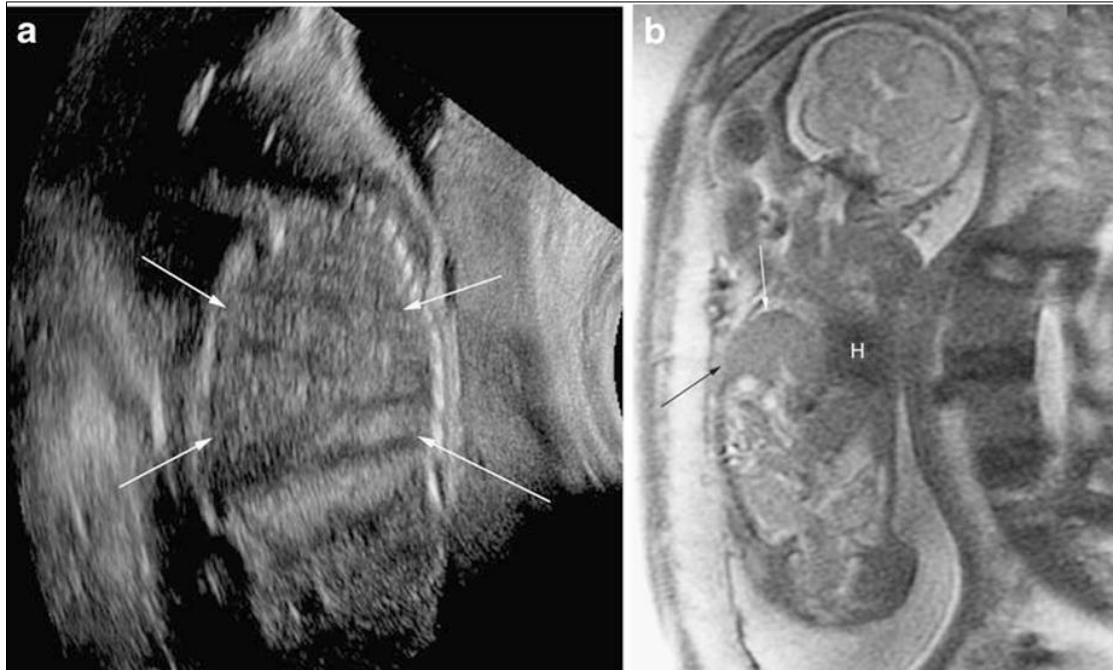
Right Bochdalek hernia in a 20-week fetus. a Sagittal sonogram of the right fetal chest shows the liver filling the right hemithorax (arrows). b Coronal T2-W MR image obtained the same day confirms the presence of a right-side Bochdalek hernia with herniation of the liver and bowel (arrows) and displacement of the fetal heart (H) to the left
